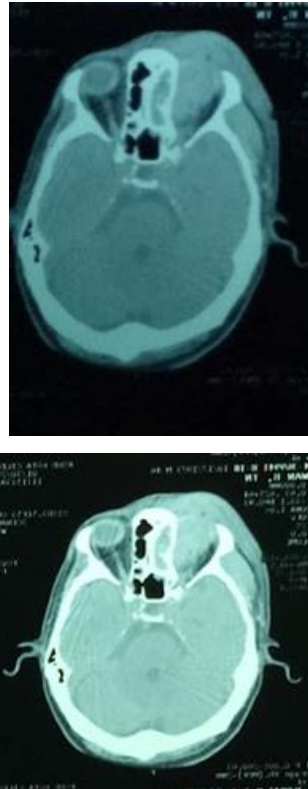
CT-scan examination
